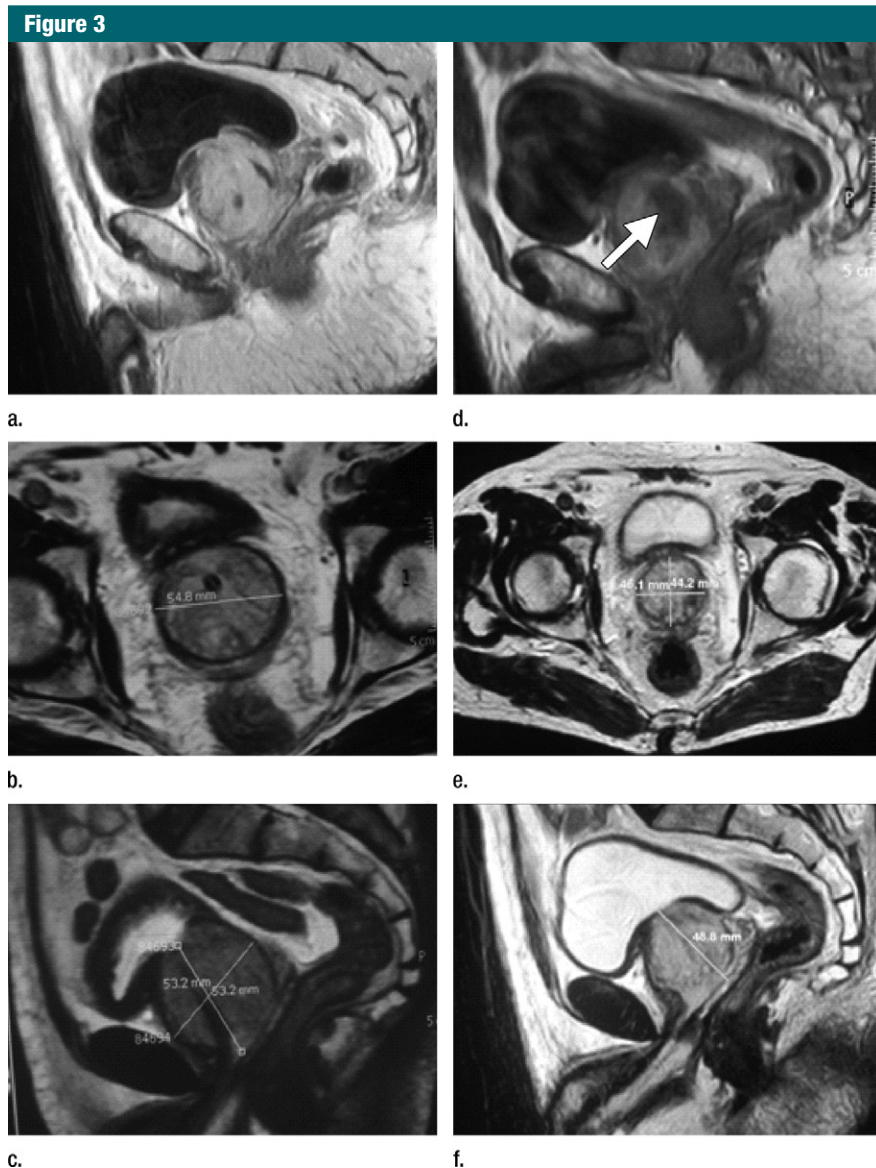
MR images in 76-year-old man with BPH. Patient had undergone medical treatment for 6 years. Peak urinary flow was 5.2 mL/sec. Images were obtained (a–c) before and (d–f) 3 months after PAE. Prostate volume was 81.1 mL ($53.2 \times 53.2 \times 54.8$ mm) before PAE and 53 mL ($46.1 \times 44.2 \times 48.8$ mm) 3 months after PAE, a reduction of 35%. Note central gland nonenhancement (arrow in d) with intravenous contrast material owing to ischemia.
